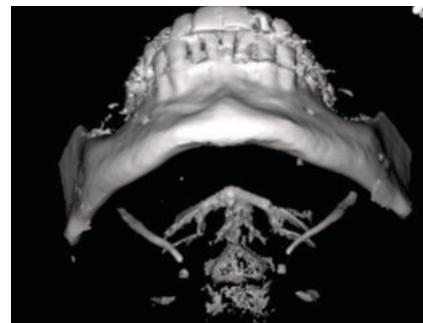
CT scan 3D reformatted image showing elongated styloid processes.
